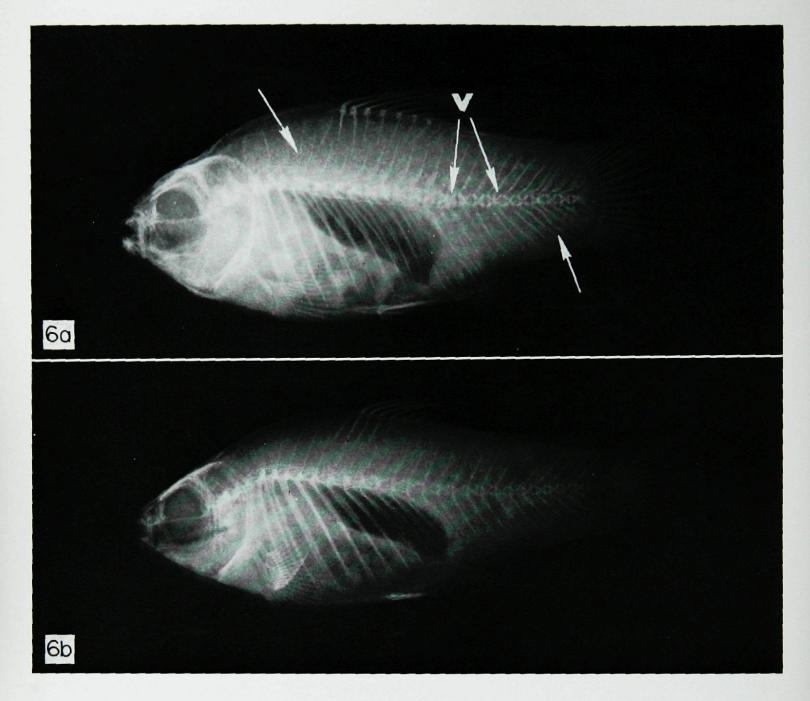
Radiographs of control, normal sheepshead minnow (b) and minnow (a) exposed to $16.6 \, \mu g/l$ trifluralin for 51 days and then depurated for 41 days. Compare the regular period of neural and haemal spines in the control to the irregular and displaced pattern in the exposed fish (arrows). Exposed fish has enlarged, dysplastic (malformed) vertebrae (V) with irregular articulations between vertebrae (×2.5).
